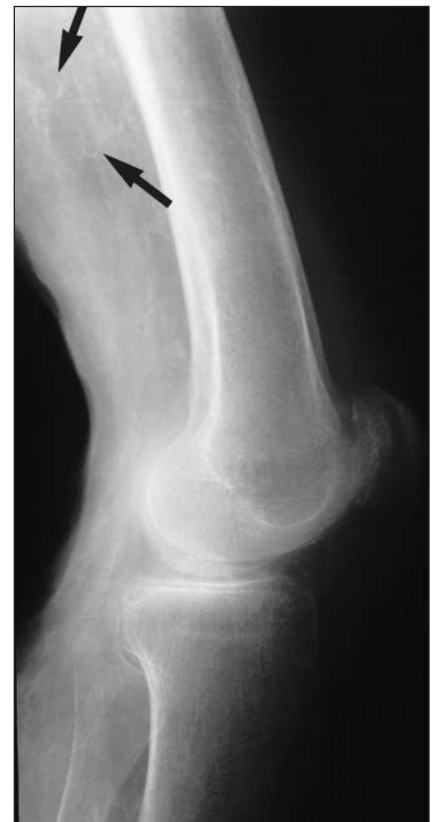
Radiograph of the left leg. The arrow shows calcified small blood vessels.
